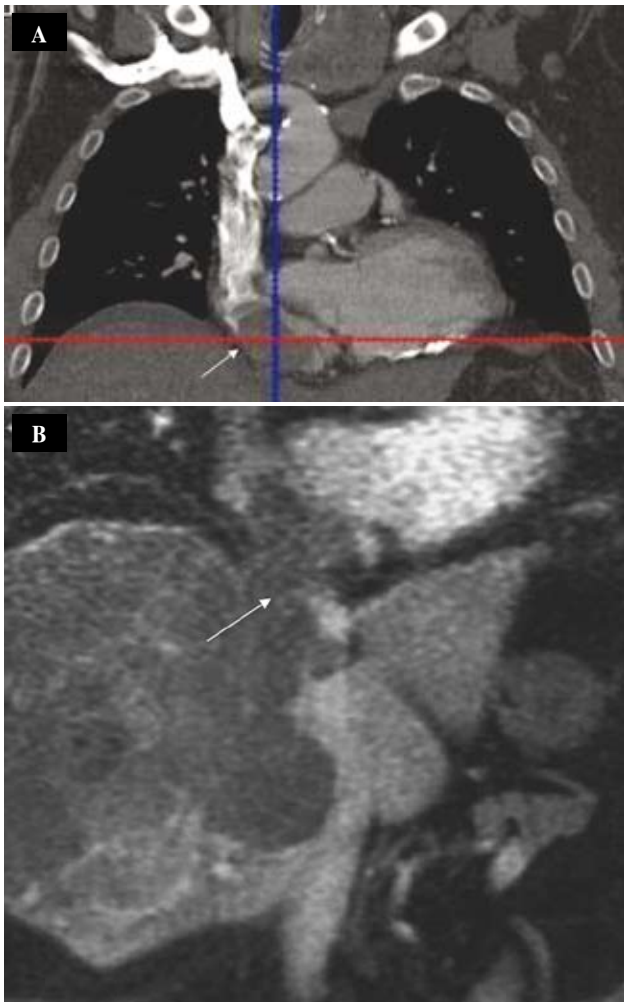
A, B. Massive venous thrombosis with cardiac invasion as primary manifestation of hepatocellular carcinoma. Coronal view CT (a), MRI (b).
